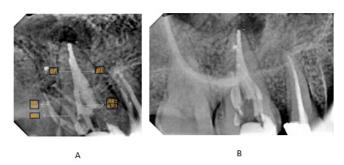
(A and B) Post-operative radiograph straight and mesial angle views.
